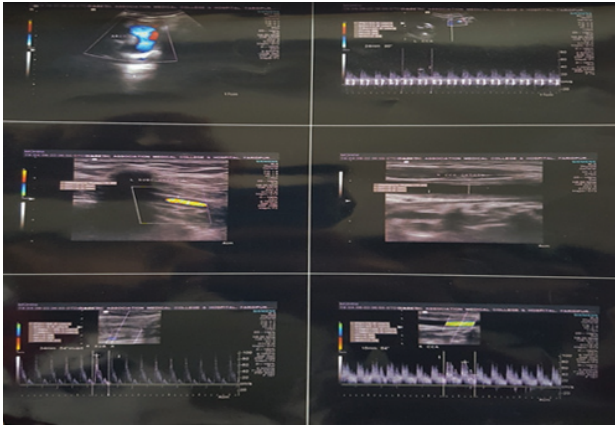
Duplex colour doppler study of arch of aorta and its branches shows significant narrowing of RCCA, LCCA, Left subclavian artery consistent with Takayasu's arteritis.
